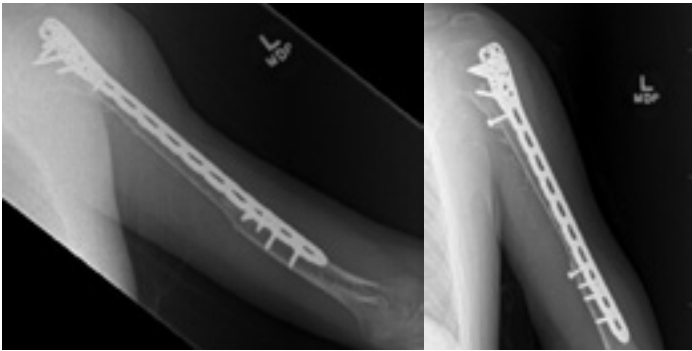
X-rays obtained 10 months after surgery demonstrating graft incorporation.
